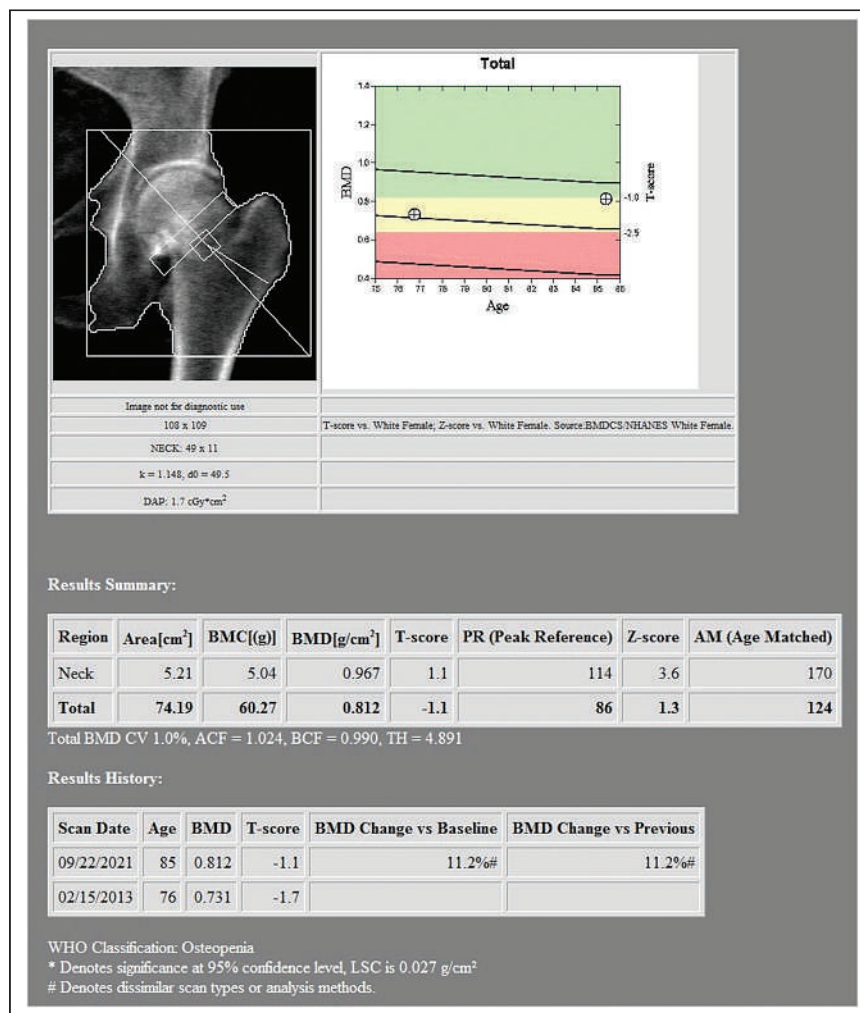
Dual-energy x-ray absorptiometry image suggesting foreshortened femoral neck. AM = age matched; BMC = bone mineral content; BMD = bone mineral density; DAP = dose area product; BMDCS/NHANES = Bone Mineral Density in Childhood Study/National Health and Nutrition Examination Surveys; LSC = least significant change; PR = peak reference; WHO = World Health Organization.
